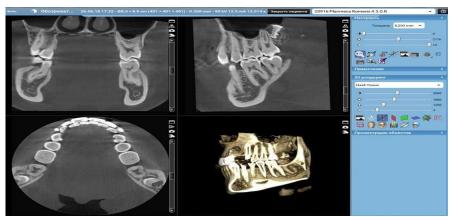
3-D computed tomography for inflammatory-dystrophic periodontal lesions.
